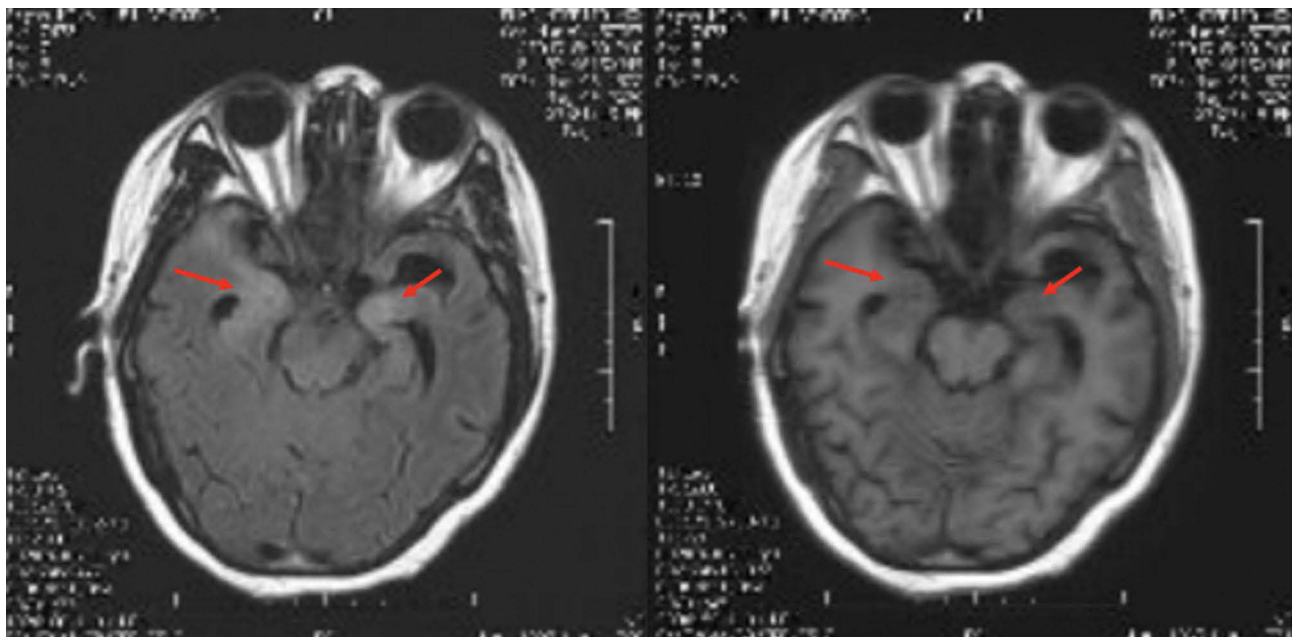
MRI findings of neurosyphilis in T2 and T1. A 48-year-old female patient was admitted to our hospital due to cognitive impairment and was diagnosed with neurosyphilis. MRI reported lesions at the bilateral medial temporal lobe (red arrow), showing a high signal on T2 (left) and a low signal on T1 (right).
